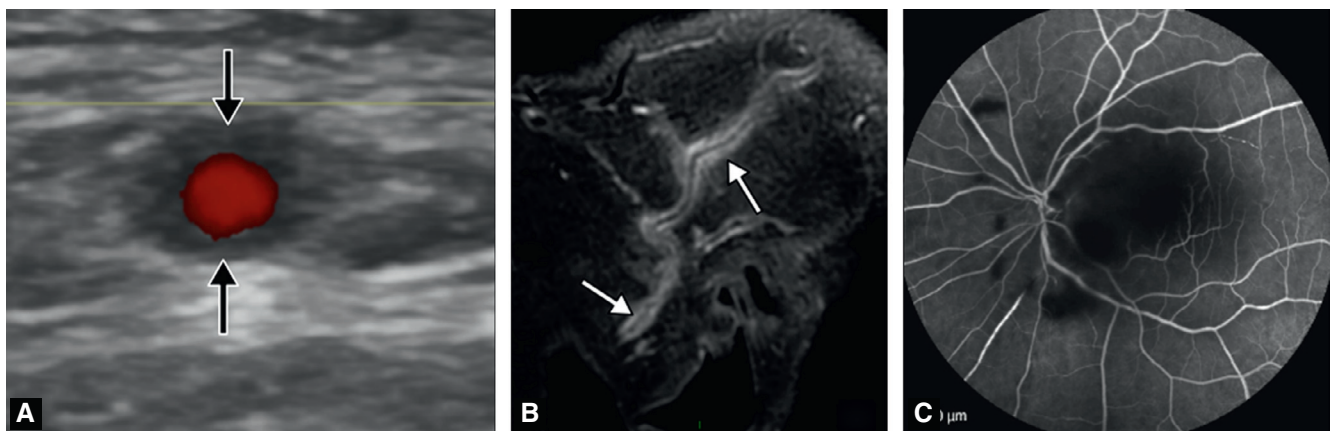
96-year-old man with a positive diagnosis of GCA. Ultrasound image (a) shows a halo sign and a thickened arterial wall of the right temporal artery (black arrows). High-resolution vessel-wall MRI (b) shows grade 3 inflammatory changes of the right temporal artery (white arrows). Retinal angiography (c) shows choroidal delay in the territory of the short medial posterior ciliary artery.
